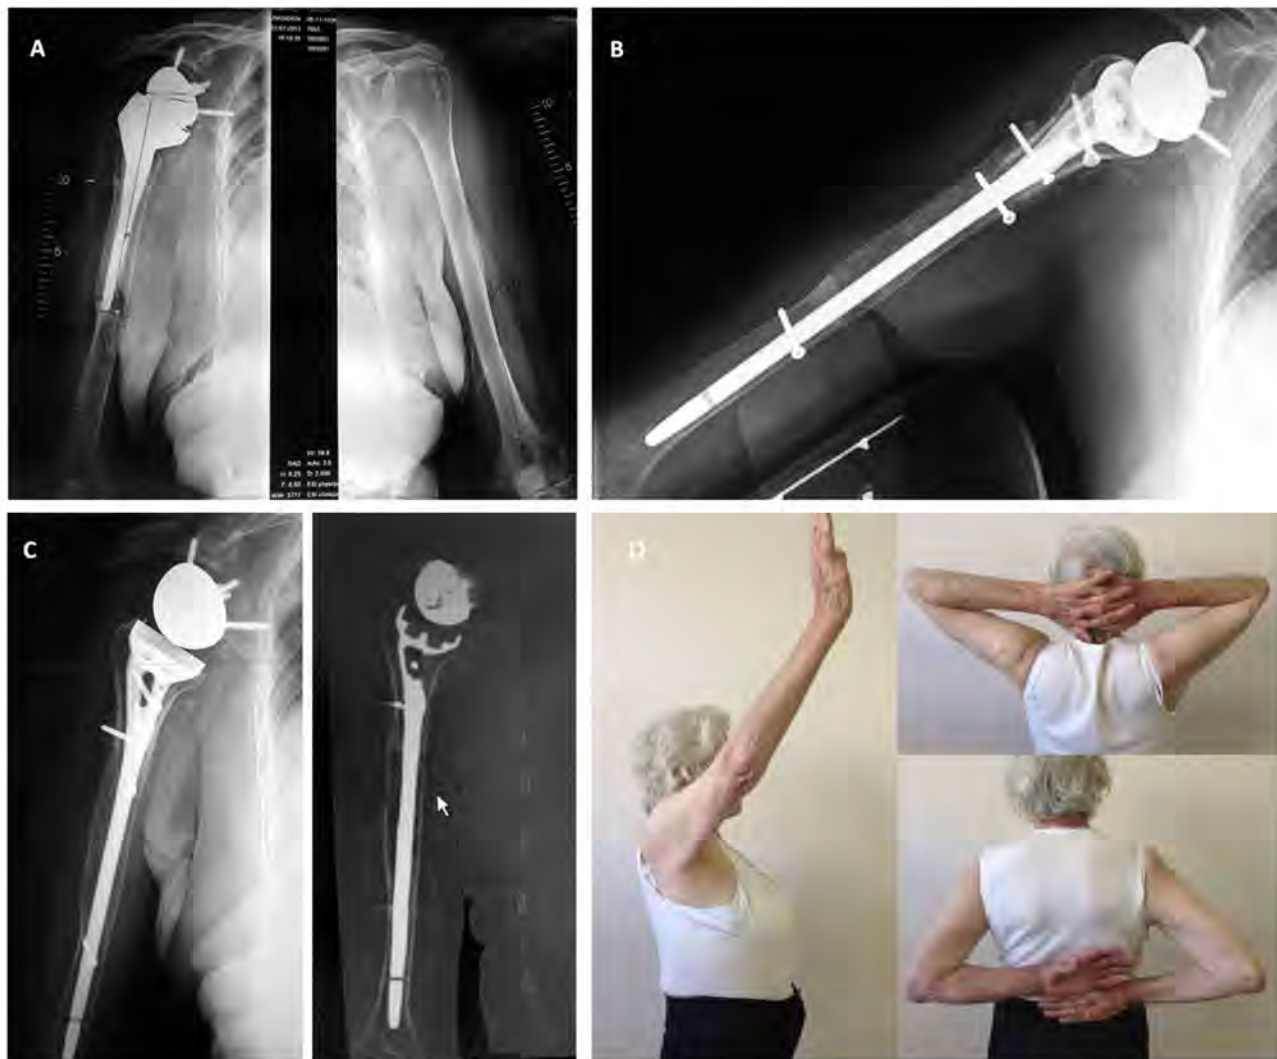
Example of humeral loosening 7 years after RSA. A. Radiograph with millimeter scale of both humeri, quantifying bone loss and theoretic height of humeral component. B. Immediate postoperative radiograph: proximal defect (–5 cm) reconstructed by uncemented locked prosthesis with humeral allograft. C. Radiography and CT at 2 years, showing allograft consolidation onto native humerus (“step-cut” is useful to control rotation). D. Functional result at 2 years.
